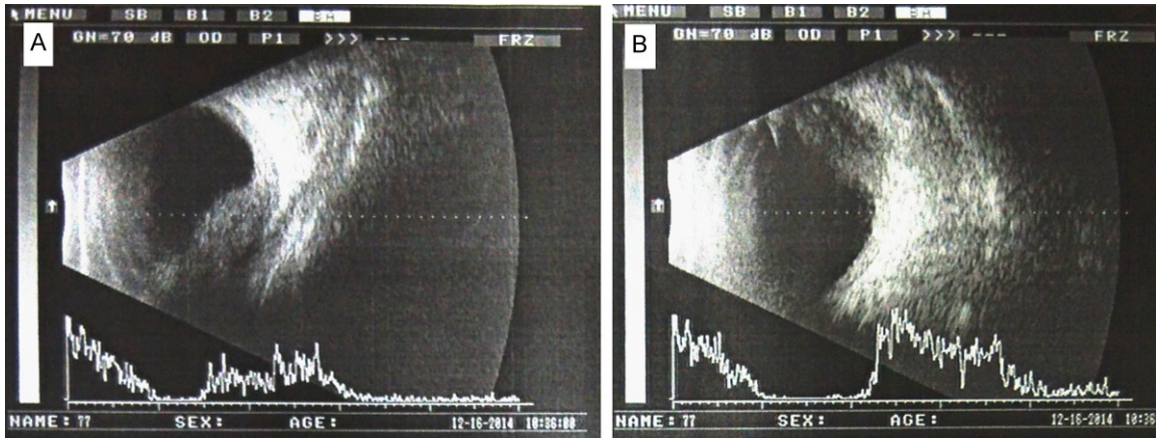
B-ultrasonography showed an abnormally hyperechoic area behind the right eyeball with incomplete boundary (A, B).
